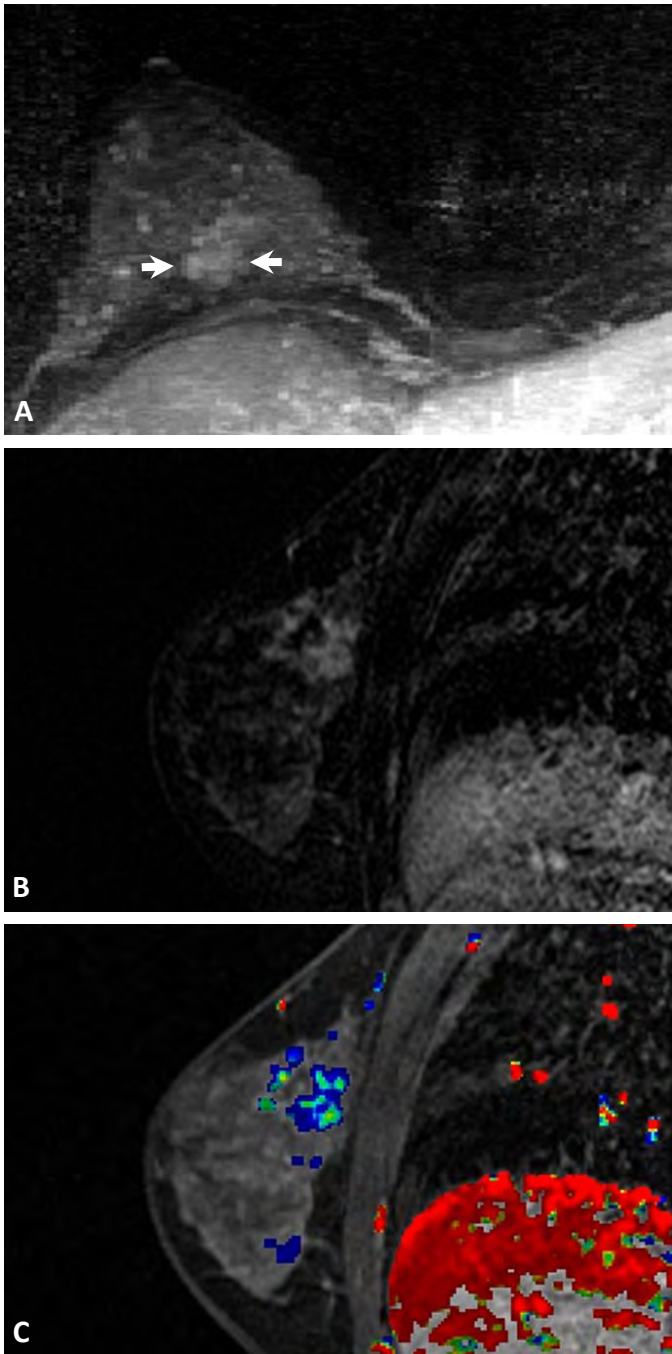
Variable MRI enhancement kinetics of DCIS. (A) axial MIP and (B) sagittal subtraction post-contrast images reveal clumped, segmental non-mass-like enhancement (white arrows) in the right upper inner breast. (C) Sagittal CAD overlay demonstrates mixed plateau and persistent delayed enhancement curves represented by the green and blue color coding, respectively.
